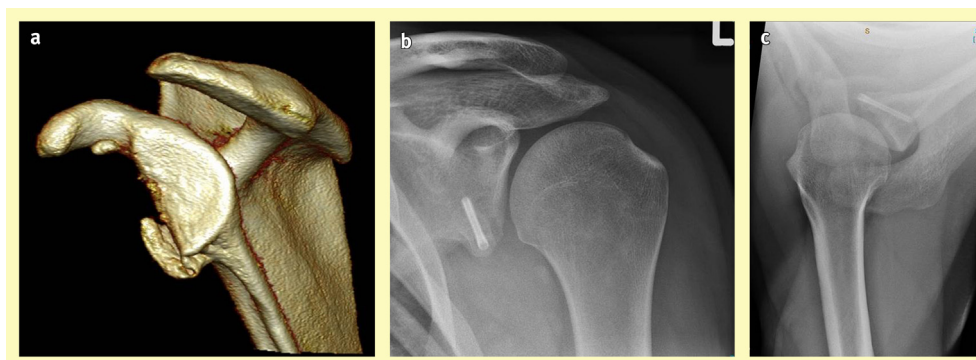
(a) CT image of a chronic bone Bankart lesion in a high school rugby player. This patient could not raise his arm overhead without the shoulder subluxing. (b) AP X-ray and (c) axial X-ray of the same player following Bristow–Laterjet procedure.
